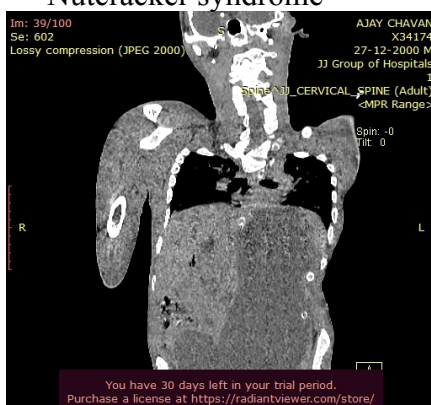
Contrast CT scan of the abdomen and pelvis showing gross dilatation of stomach
